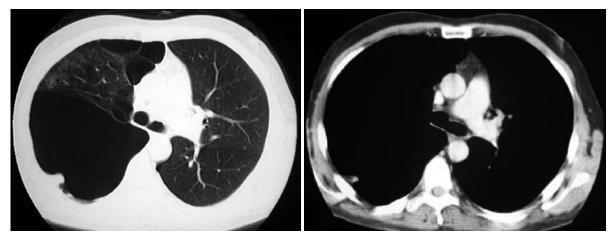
Chest computed tomography showing a giant bulla and a nodular lesion in the bulla wall in the upper right lobe.
